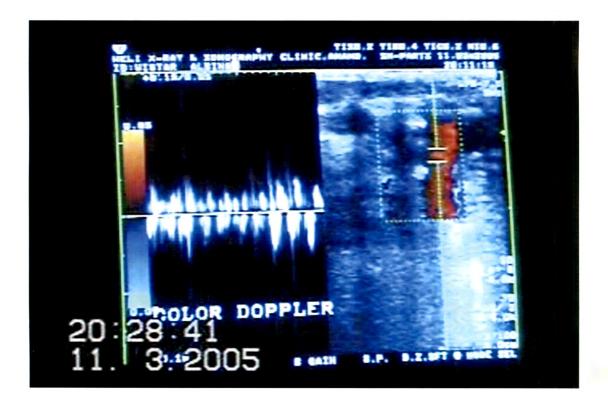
A Cardiac image showing heart rate in conventional imaging (Color Doppler) after administration of microbubbles
